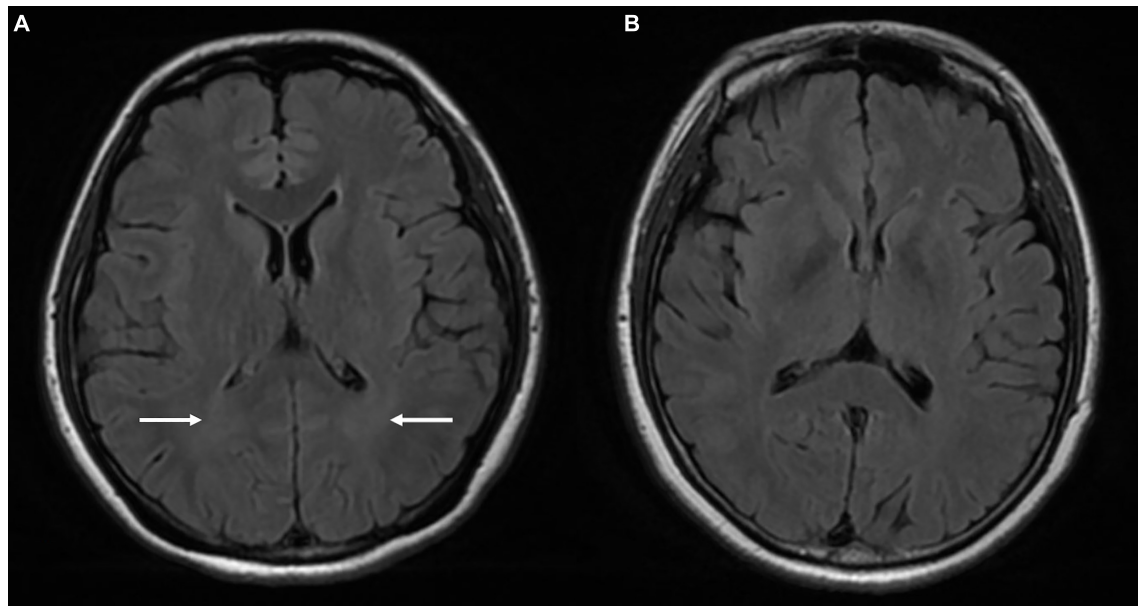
Comparison of the MRI findings between a 33-year-old female patient with TSS (A) and a 42-year-old female healthy control (B). Venous PT patient with TSS: T2 FLAIR (A) shows symmetrical cloud-like WM hyperintensity in the bilateral periventricular area (white arrow) that was absent in the healthy control (B). PT, pulsatile tinnitus; TSS, transverse sinus stenosis; FLAIR, fluid attenuated inversion recovery; WM, white matter.
